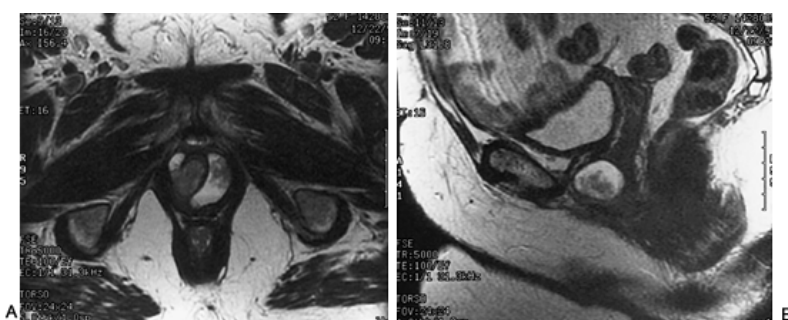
Magnetic resonance imaging scan of adenocarcinoma of the female urethra involving a urethral diverticulum. A: Coronal T₂-weighted image demonstrates a polypoid soft tissue mass within a left urethral diverticulum. B: Sagittal T₂-weighted images of the diverticulum and soft tissue mass.
